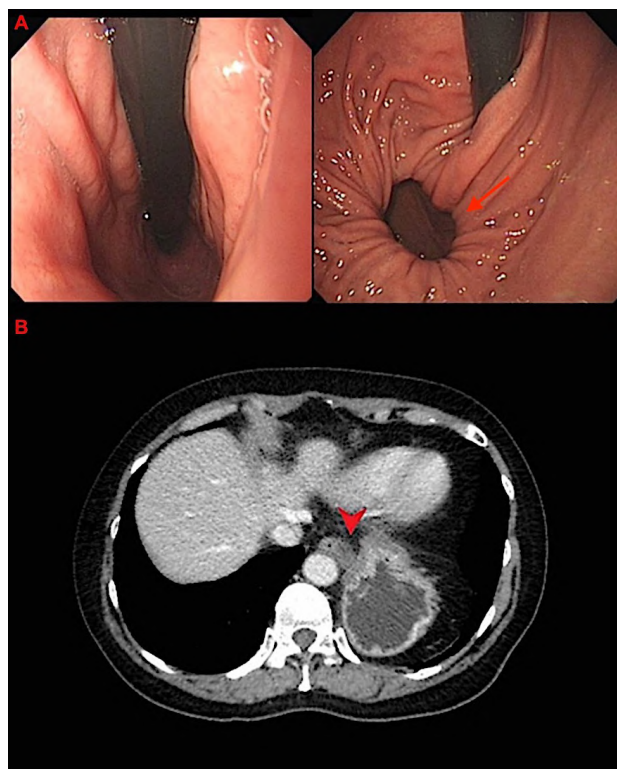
Preoperative study case 1. A: gastroscopy (arrow: herniation in parahiatal fashion). B: CT scan (arrowhead: parahiatal defect).
